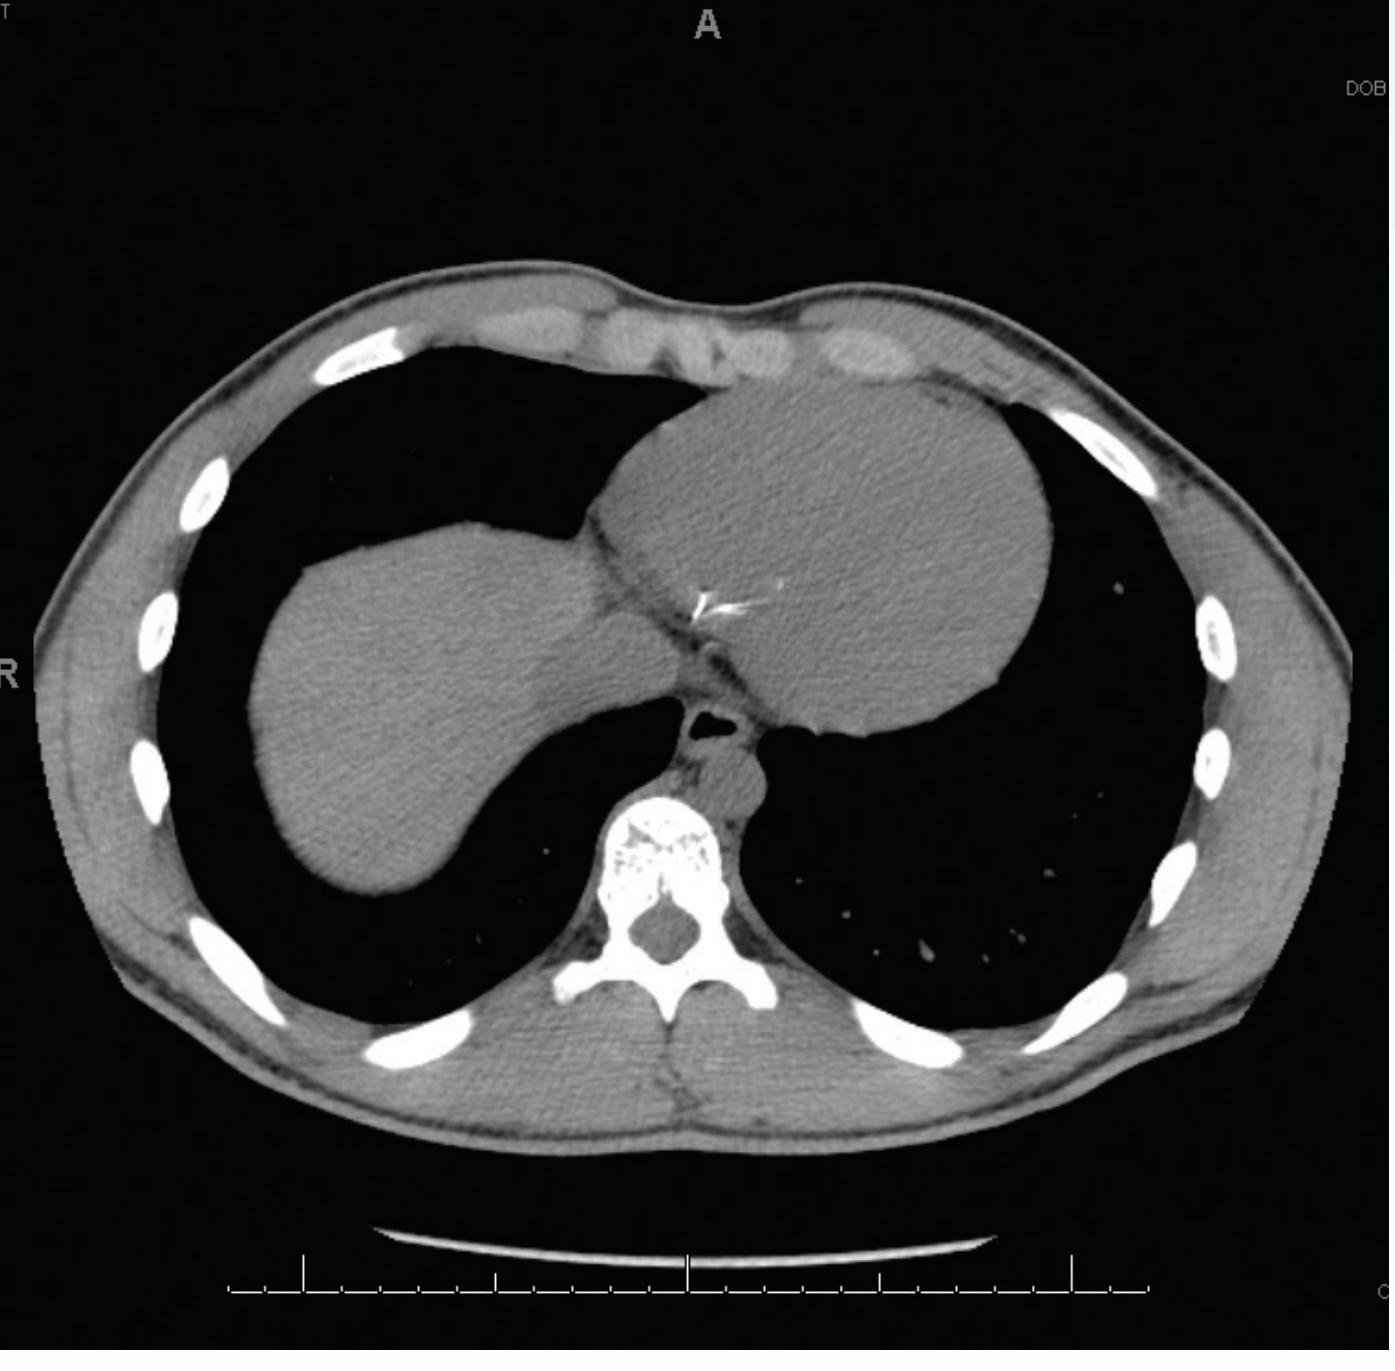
CT scan of the chest with centering strut visualized in right atria 1/29/10
